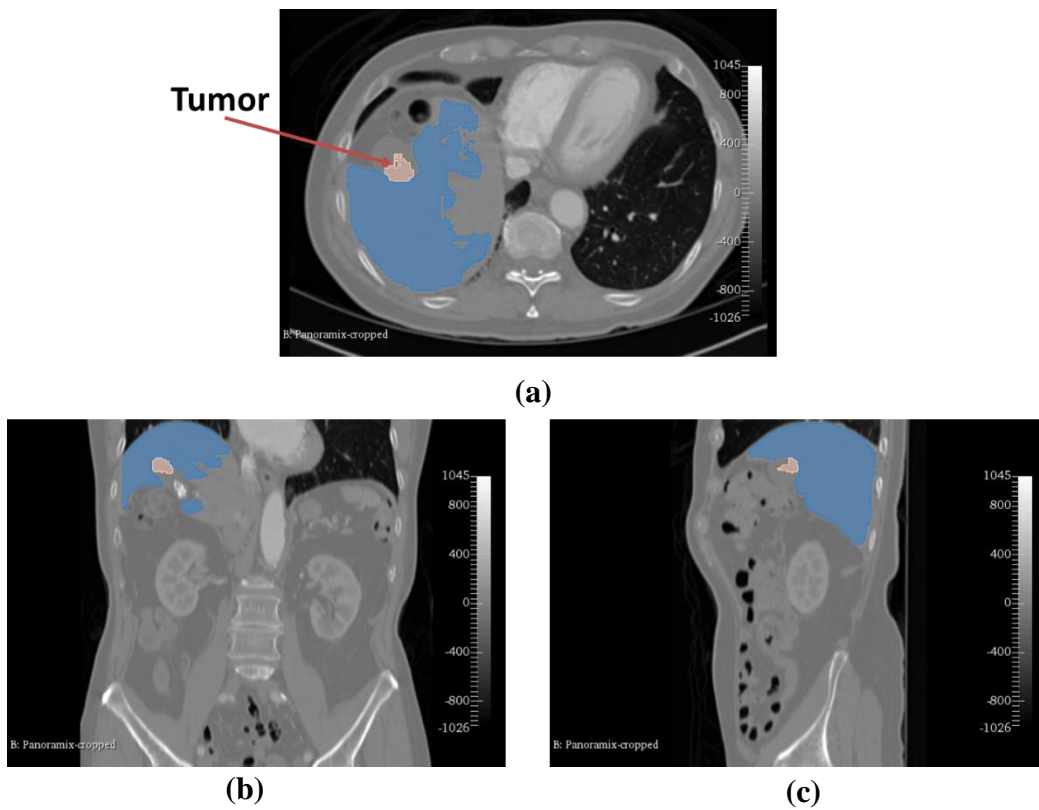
Computed tomography images of liver and tumor in the (a) axial, (b) coronal, and (c) sagittal plane
